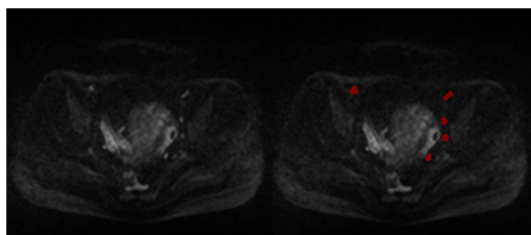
The original DWI (left) and the corresponding automatically processed image by CAD (right), where lymph nodes were labeled in red.
